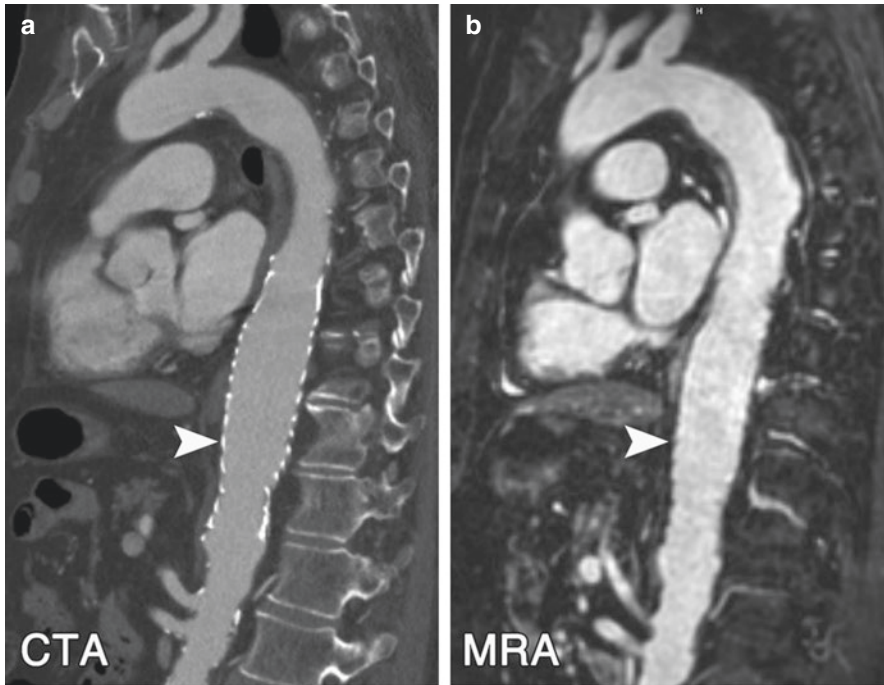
Post-Endograft Surveillance with MRA*: Sagittal images of a patient with penetrating atherosclerotic ulcer of the descending aorta who underwent TEVAR using a nitinol endograft. The metallic endograft can be clearly seen on CTA images (a, arrow head). While the endograft material appears dark/black on MRA images (b), the nitinol doesn't create any significant artifact in the image and detailed evaluation of the lumen and surrounding anatomy is possible
